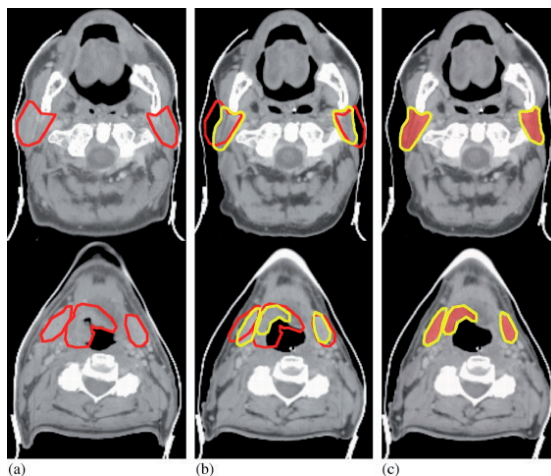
Example of observed shape and position changes for head-and-neck patient (bilateral neck treatment). (Upper) Parotid glands and (Lower) submandibular glands and primary tumor. (a) Planning computed tomography (CT) scan and delineated structures in red. (b) Post-external beam radiotherapy (EBRT) CT scan with planning (red) and post-EBRT CT scan (yellow) delineations. (c) Post-EBRT CT scan with delineated structures (yellow) and transformed planning structures (red shadow).
